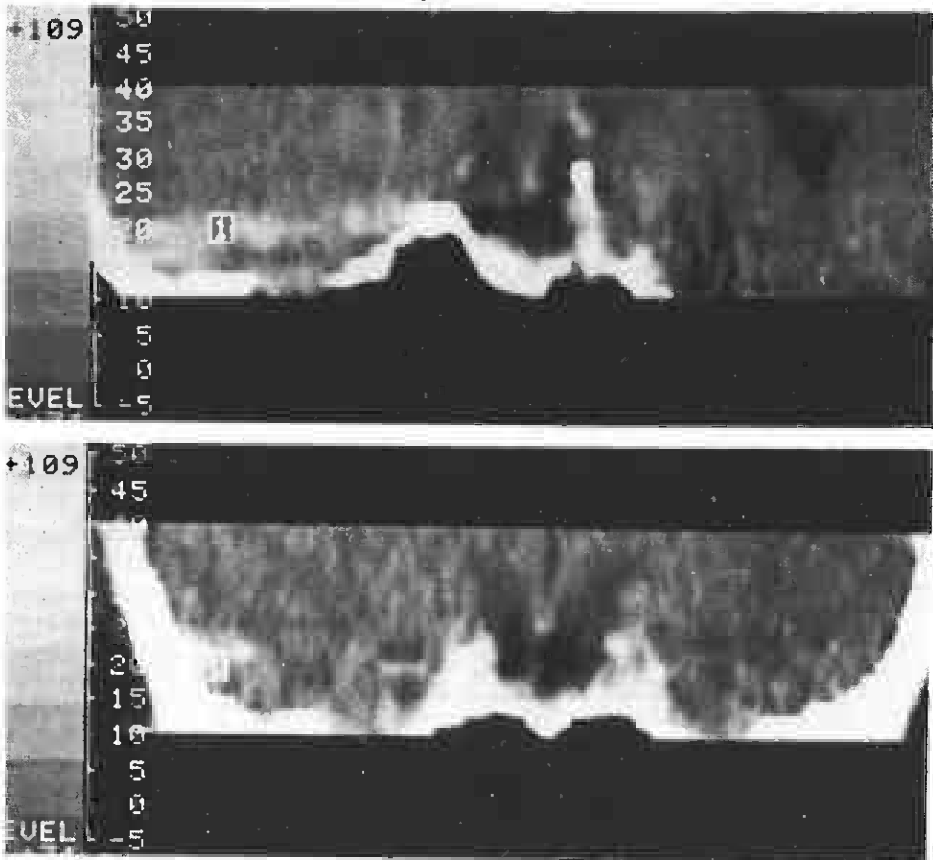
Sagittal (top) and coronal (bottom) reconstructions of the CT scan of the same patient after 1 year of bromocriptine as sole therapy. The macroprolactinoma has largely disappeared and the sella is almost empty.
